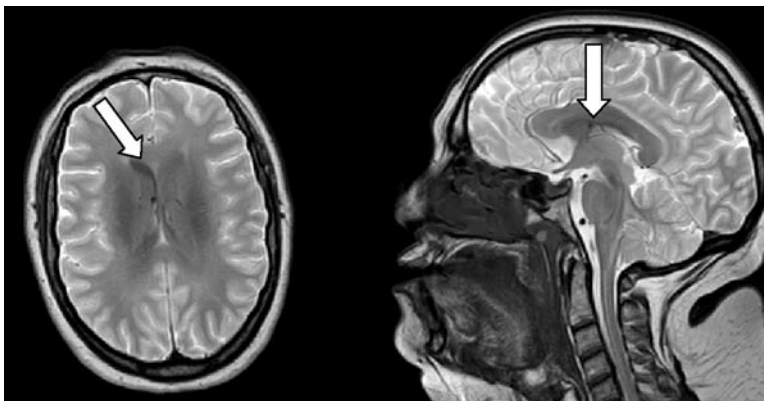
T1 weighted transverse and sagittal MRI images showing decreased intraventricular and intracerebral gadolinium accumulation on day #2.
